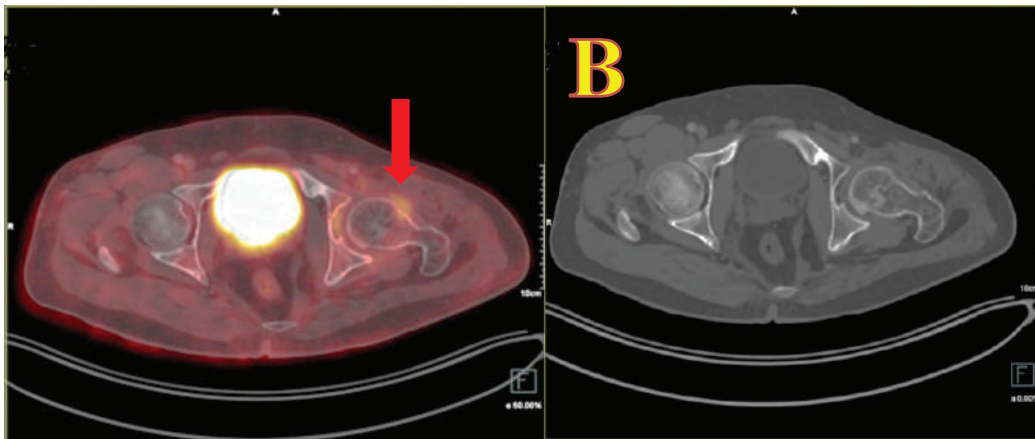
FDG PET/CT axial view showing diffuse low-grade uptake in the soft tissue around left femoral head (red arrow), fusion image (A), CT image (B).
